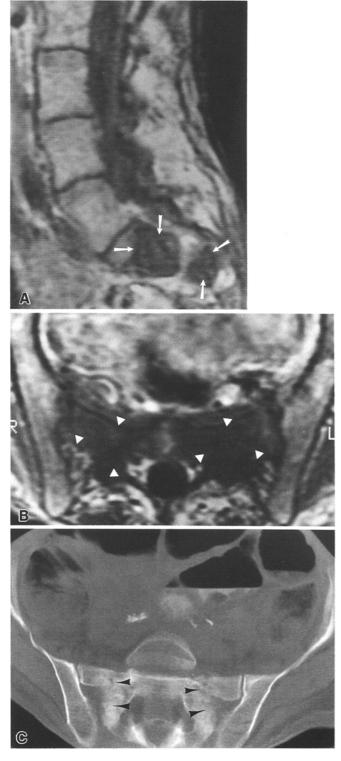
Sacral insufficiency fracture in a patient with a primary colonic carcinoma, treated surgically without evidence of previous metastatic desease, presenting with low back pain. A Sagittal T₁-weighted MR image demonstrates two areas of low signal intensity within the sacral body (arrows). B Axial T₁-weighted MR image demonstrates large, rounded areas of decreased signal attenuation involving most of the sacral body (arrowheads). These findings were believed to be highly suspicious of metastatic disease. C CT scan (bone windows) clearly delineates fracture lines with surrounding sclerosis (arrowheads)
